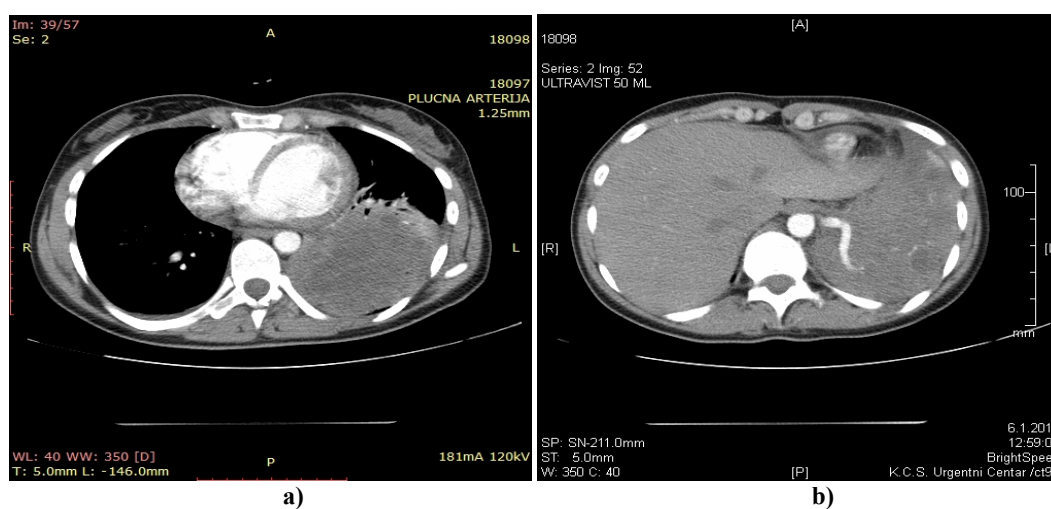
a) Thorax computed tomography (CT) scan: multicystic mass in the left lower lobe; b) Thorax CT scan: aberrant artery arises from the descending thoracic aorta.
